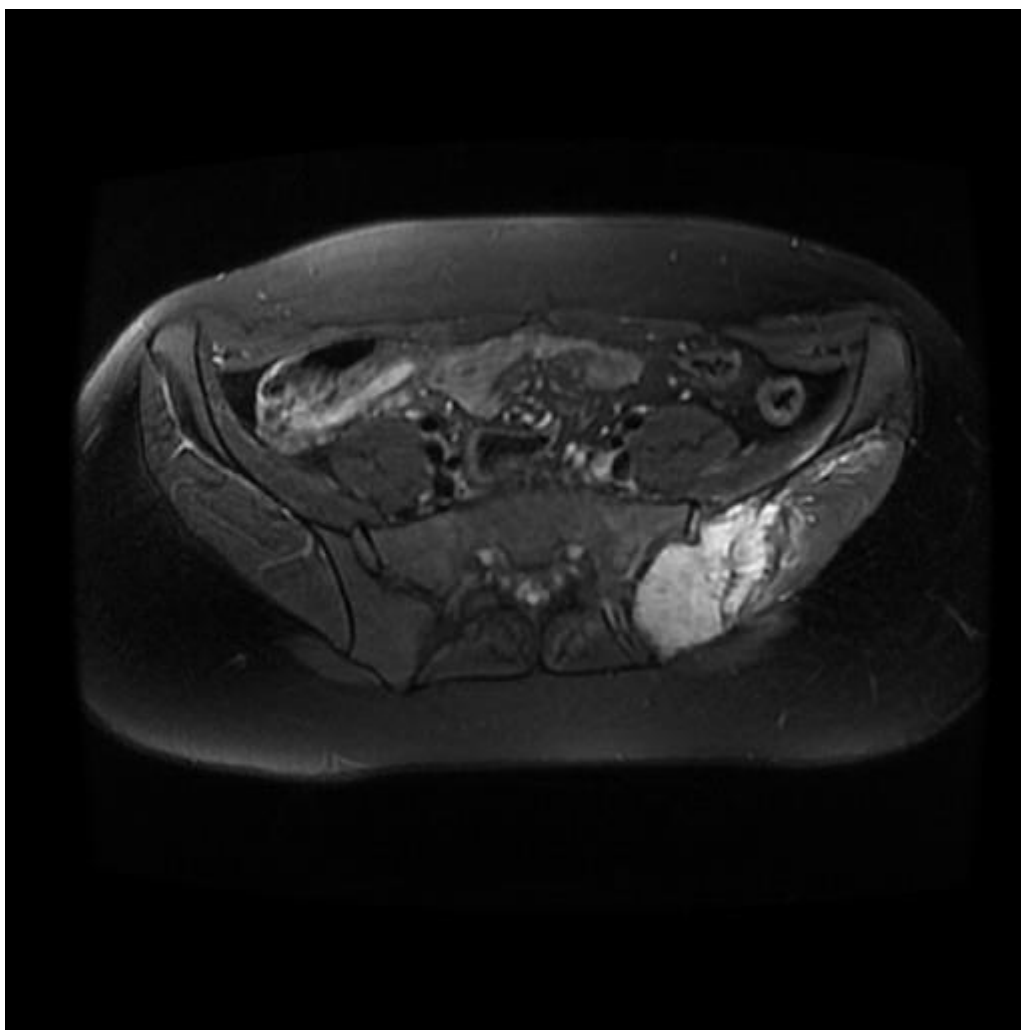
An axial view of a MRI scan showing shrinkage of the tumour following chemotherapy treatment
